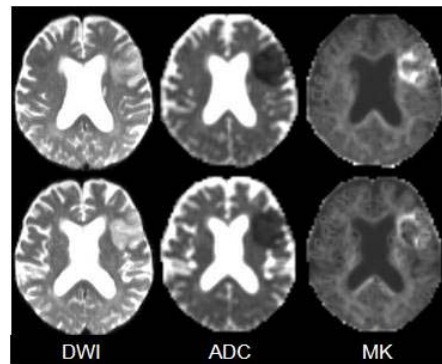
DWI, ADC and MK maps from two adjacent slices from a 74 year old woman with aphasia and weakness of her right hand. Here, DWI, ADC and MK delineate the same anatomical region of acute ischemia in the left frontal-parietal lobe. DWI and ADC are isointense within the region, whereas MK shows a heterogeneous appearance.
